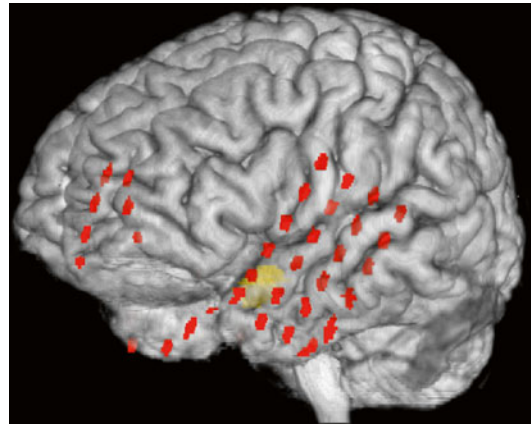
3D reconstruction of a registered image data set. Cortical surface was rendered from MRI and red dots represent subdural EEG electrodes that were imaged with CT. The functional epileptogenic focus (orange) was defined by interictal ^{18}F -FDG PET and ictal ECD SPECT
